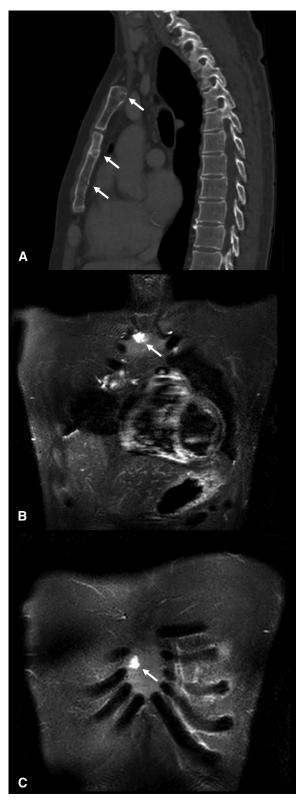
Preoperative computed tomography (A) and magnetic resonance imaging (B and C) demonstrating sternal manifestations of Maffucci syndrome.
